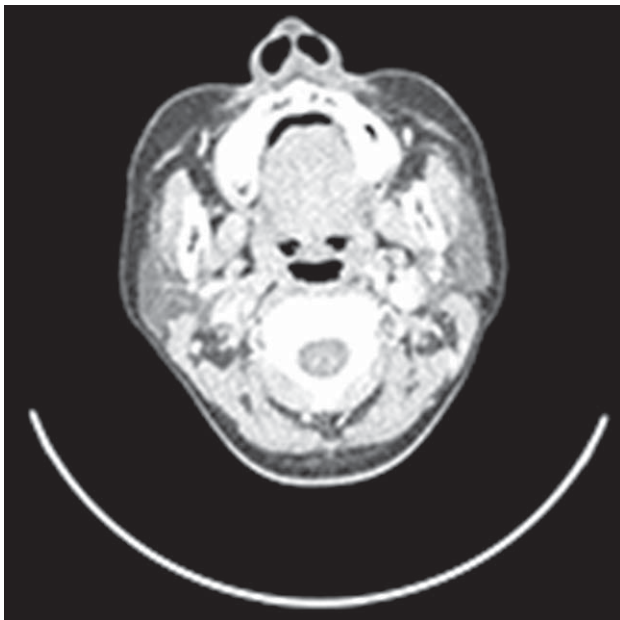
CT of the neck with contrast revealed increased subcutaneous fat over the left parotid tail with mild mass effect onto the underlying deep cervical fascia
